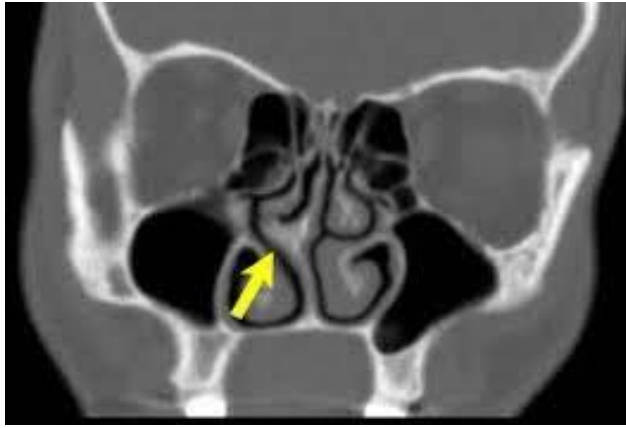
CT nose and paranasal sinuses showing deviated nasal septum.
